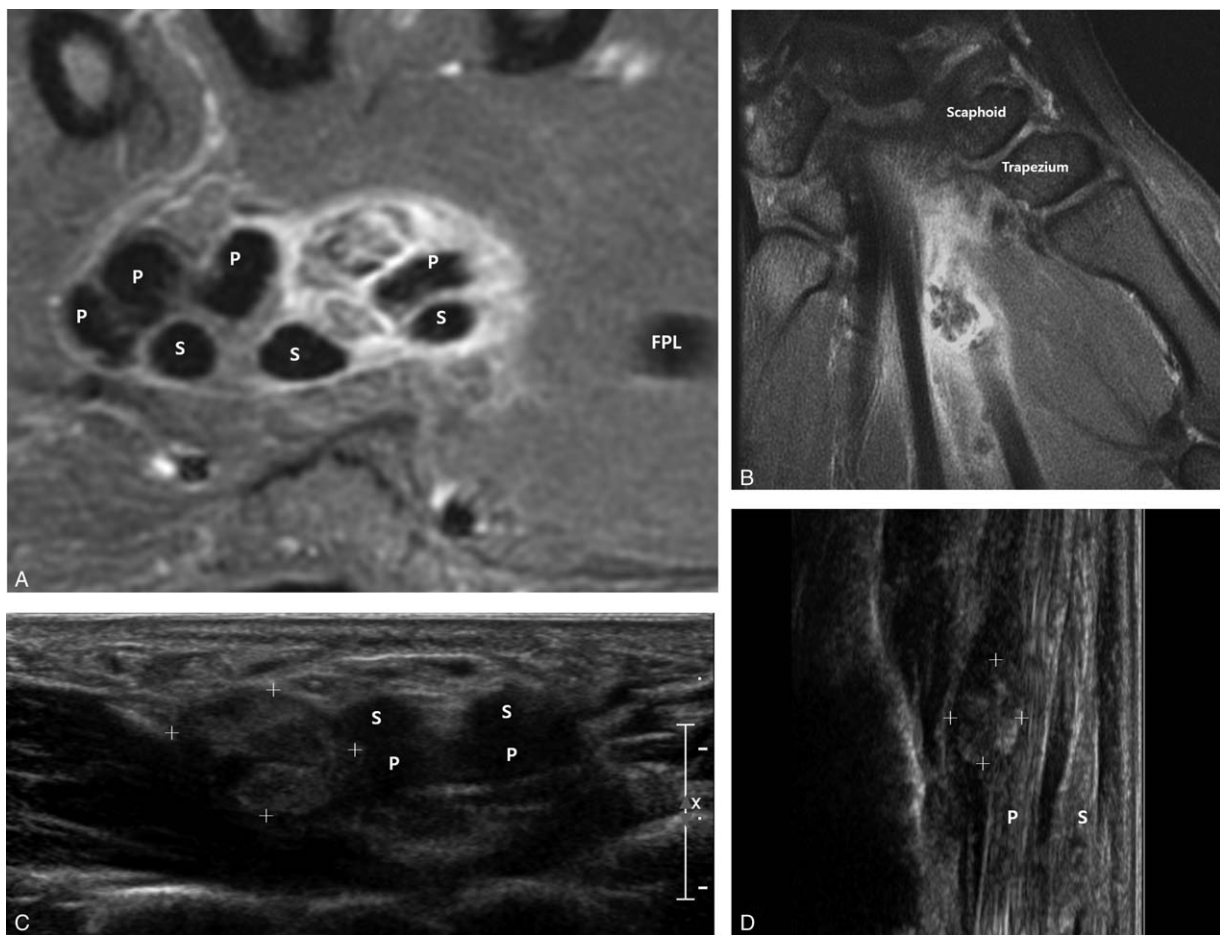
Synovial osteochondromatosis of the right hand in a 45-year-old woman presenting with a tingling sensation. (A, B) T1-weighted contrast enhanced axial (A) and coronal (B) radiographs showing synovial thickening and an osteochondral fragment surrounding the second flexor tendon. (B) Image of an osseous nodule at the proximal metacarpal level. (C) Transverse ultrasound of the right side of second flexor tendon showing multiple echogenic foci with shadowing (cross marks). (D) Longitudinal ultrasound showing multiple echogenic foci with shadowing (cross marks) beneath the flexor tendon. S = flexor digitorum superficialis tendon, P = flexor digitorum profundus tendon, FPL = flexor pollicis longus tendon.
